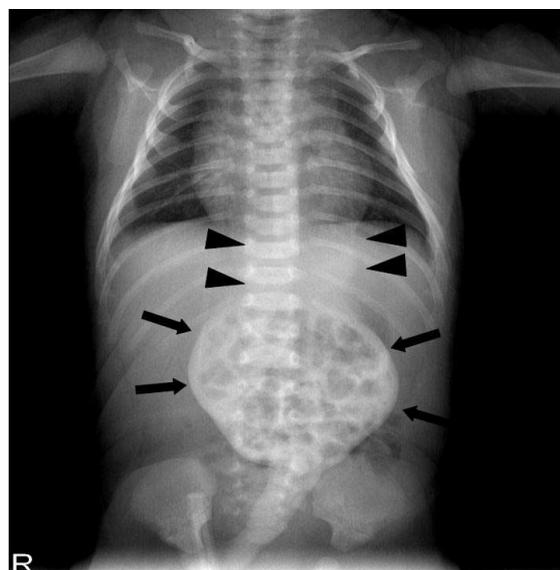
A simple radiograph shows two types of abnormal densities: a well-defined solid mass in the upper abdomen (arrowheads), and a well-defined gas-containing round lesion in the middle and lower abdomen (arrows).
